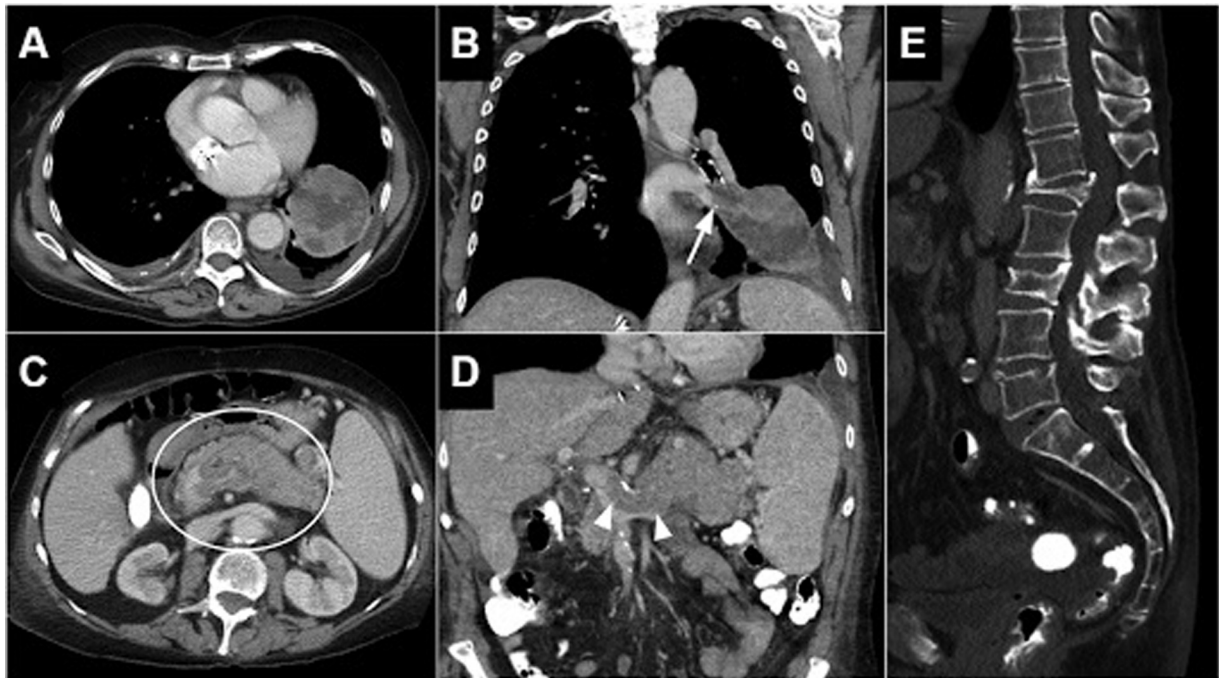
(A, B) Axial and coronal computed tomography (CT) of the chest with IV contrast demonstrating large 10 × 7 cm solid left lower lobe pulmonary mass with central necrosis, infiltrating the left inferior pulmonary vein (arrow). Bilateral small pleural effusions were present. (C, D) Axial and coronal CT of the abdomen with IV contrast demonstrating an infiltrative, 10 cm hypoenhancing mass in the body and tail of the pancreas (circle). A tumor thrombus infiltrates the splenic and main portal vein (arrowheads). (E) Pathologic compression deformities at the L1 and L3 vertebra.
